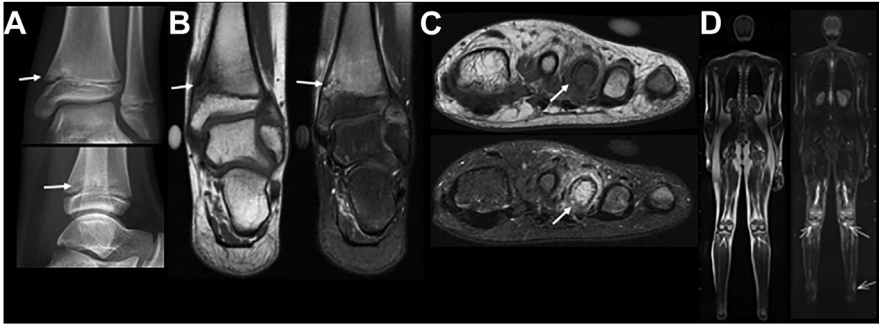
Chronic nonbacterial osteomyelitis. A 13-year-old girl with fever, pain, and swelling of the left ankle for 10 days. Radiographs (A) showing discrete hypodense foci and bone irregularities on the medial side of the distal tibial metaphysis (arrows), with bone marrow edema on T1 and T2FS MRI images (arrows) (B). Biopsy and bacterial culture did not isolate any pathogens. After 1 year, bilateral midfoot pain presented with similar MRI findings on the metatarsals (arrows) (C). Due to the clinical hypothesis, the patient was submitted to WBMRI (D) that showed other bone alteration sites, some of them asymptomatic, which contributed to the diagnosis of chronic nonbacterial osteomyelitis.
